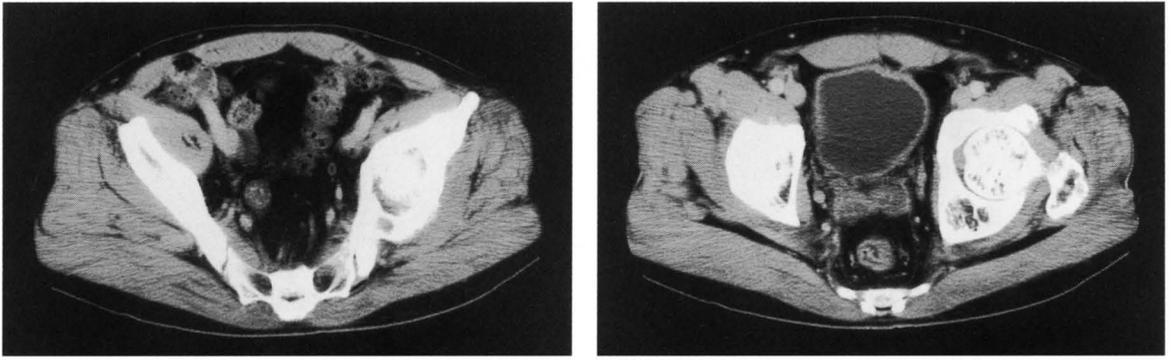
CT of the pelvis shows the metastatic lesion ,which is from the left ilium (A) to the left acetabulum (B) , disappeared one year after radiotherapy.
